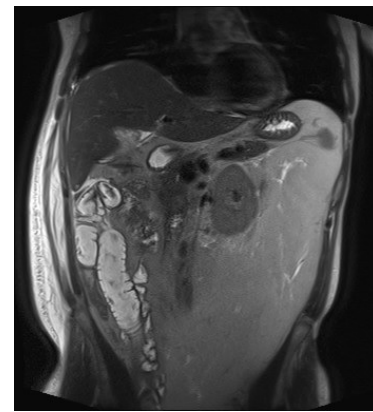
Cholangio-MRI with Bile Leak after Lap. Cholecystectomy (Axial)
